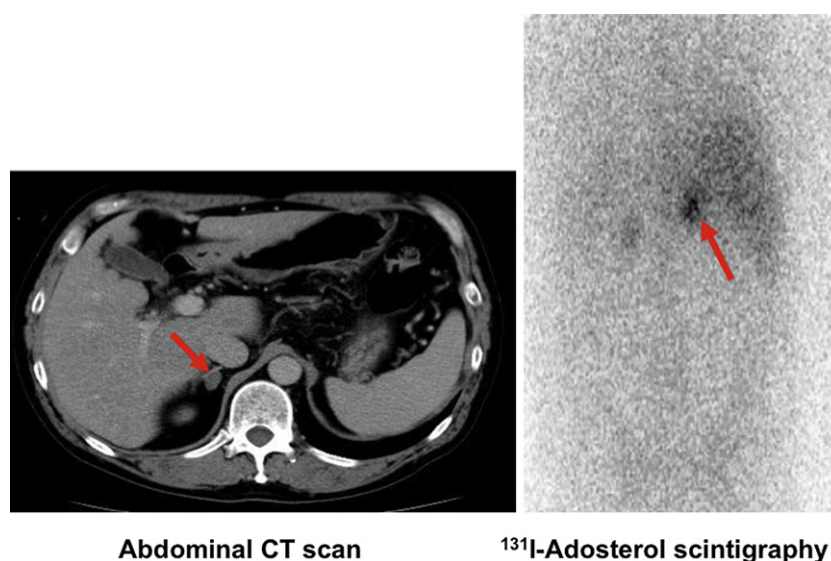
Abdominal computed tomography (CT) and ¹³¹I-adosterol scintigraphy. Abdominal CT demonstrated a right adrenal mass (13 mm × 9 mm) (left panel), which also had abnormally increased uptake of ¹³¹I-adosterol on adrenal scintigrams (right panel). Arrows indicate adrenal mass.
